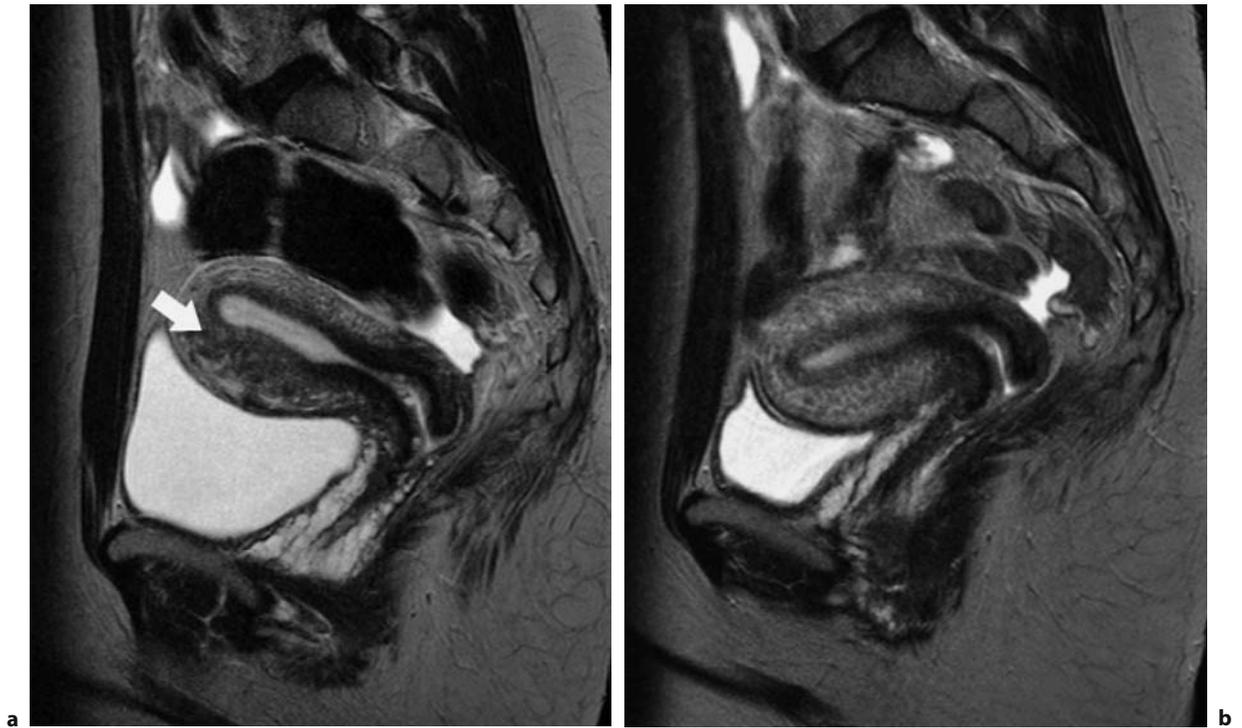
Transient uterine contraction. a T2-weighted sagittal image of the uterus depicting a broadening of the inner myometrium of the anterior uterine wall with bulging into the uterine cavity (*arrow*). b T2-weighted sagittal image of the uterus obtained 5 min before (a) shows absence of any structural abnormality, a finding consistent with myometrial contraction
